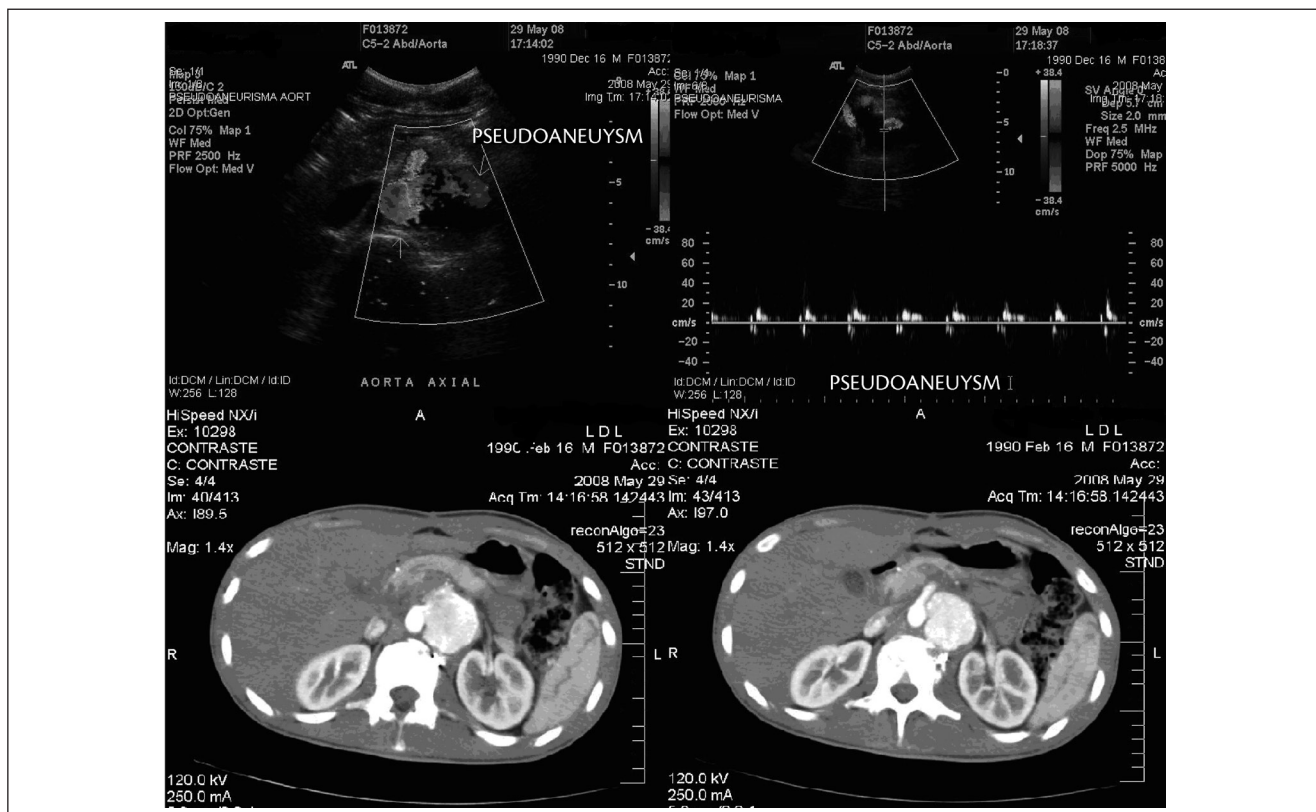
Doppler ultrasound of the abdominal aorta showing interior flow of the hematoma (above); abdominal CT scan showing the pseudoaneurysm neck and its position (below)
